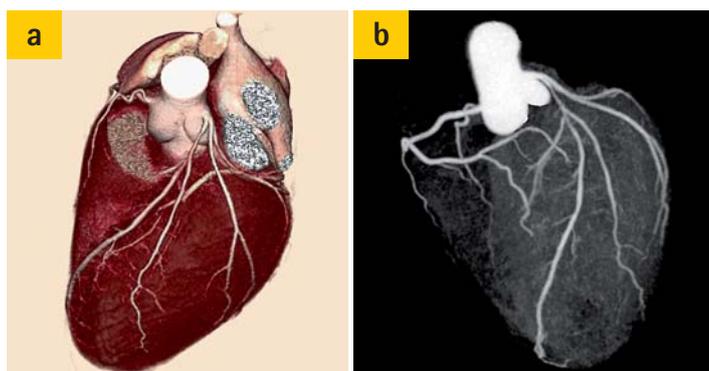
Volume rendering of the coronary CTA datasets providing very accurate visualization of coronary arteries.
